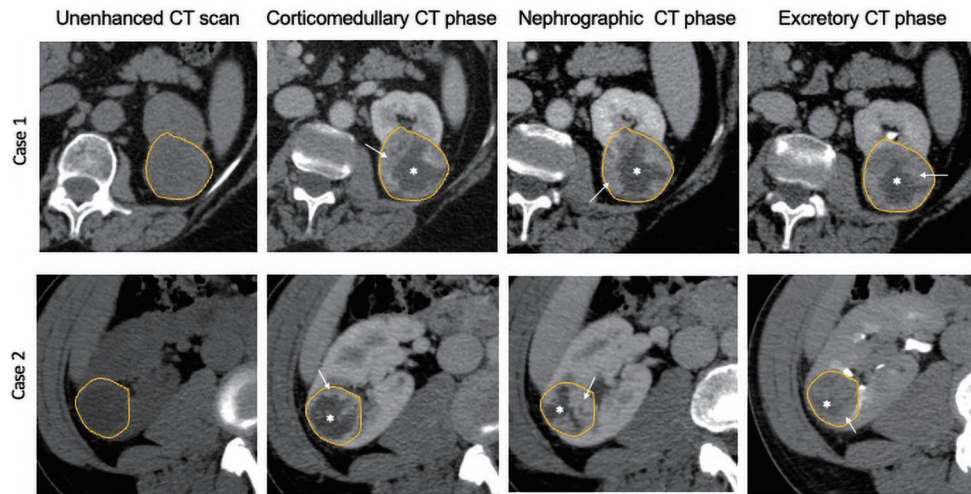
An example of 4 phase CT imaging is the following. Four-phase CT protocol (unenhanced, corticomedullary, nephrographic and excretory phases) in two cases of renal cell carcinoma (yellow ROIs in all images). Case 1 is a ccRCC of 4 cm diameter involving the upper third of the left kidney, Case 2 is a ccRCC of 3 cm involving the upper third of the right kidney. Both tumours showed similar features at qualitative assessment of each CT scan, being characterized by round shape, an hypervascular peripheral region (white arrows) and an irregular hypovascular central region (asterisks). At radiomic evaluation case 1 showed slightly lower HU in CMP and NP compared to case 2 (63 and 64 vs. 69 and 84 HU) but with higher maximum HU in both phases (168 and 139 HU vs. 120 and 106 HU) as for more necrotic lesion with higher degree of vascularization in the periphery. HU, Hounsfield Unit; CMP, corticomedullary phase; NP, nephrographic phase; ROI, Region Of Interest; ccRCC, clear cell Renal Cell Carcinoma; CT, Computed Tomography.
